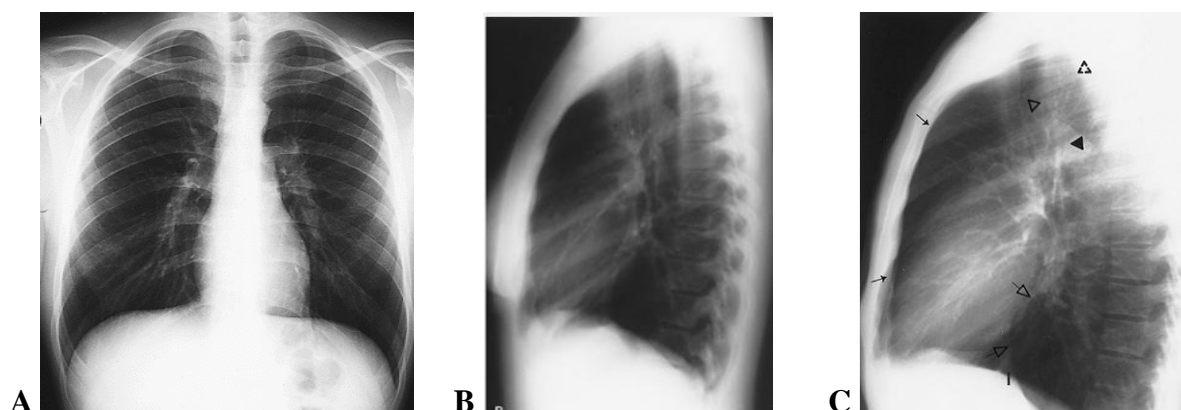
(A) Normal lung PA and (B) lateral radiographs of the chest.
